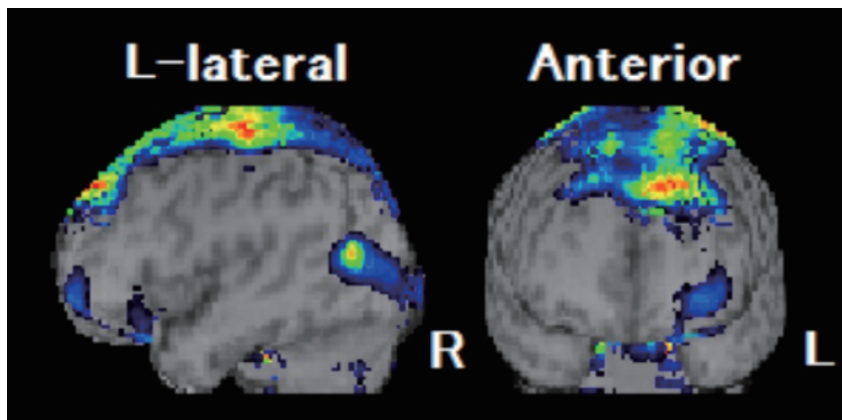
Single-photon emission computed tomography showing relatively elevated blood flow in the area of high convexity
